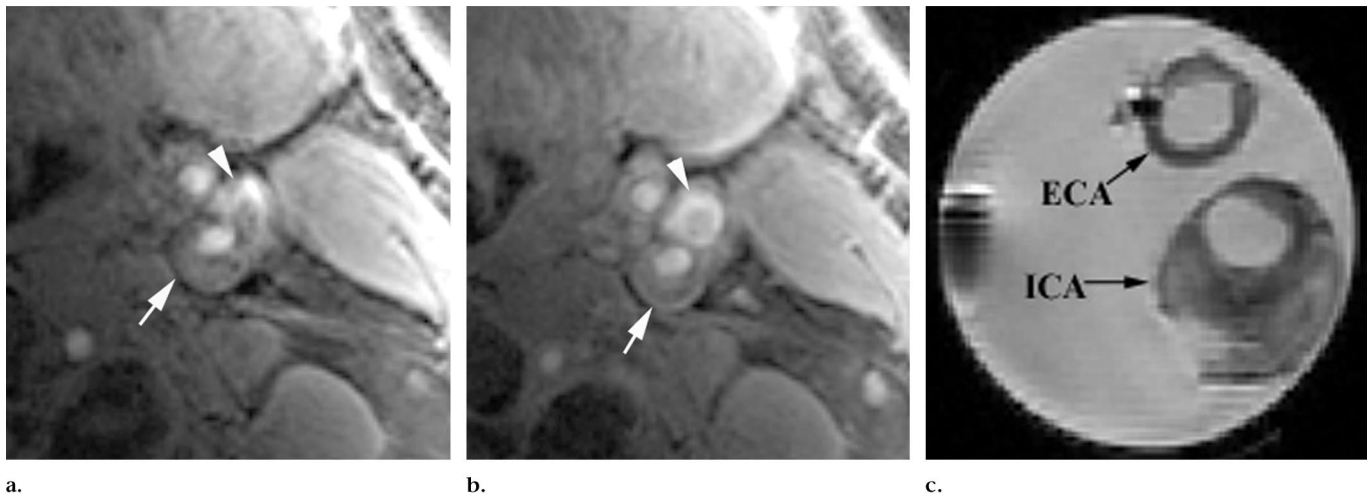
Three-dimensional fast GRE MR images of carotid artery. (a) On precontrast image, outer wall boundary of internal carotid artery (arrow) and jugular vein (arrowhead) are unclear. (b) On postcontrast image, outer wall boundary of internal carotid artery (arrow) is clearly delineated as a bright rim. Jugular vein (arrowhead) is better delineated than on a, with a clear vein-artery interface. Imaging parameters for a and b are 9.8/2.4 with a 13-cm field of view, 2-mm section thickness, matrix of 256 × 256, two signals acquired, and 20° flip angle. (c) Ex vivo image. ECA = external carotid artery, ICA = internal carotid artery. Imaging parameters are 9.8/2.4 with an 8-cm field of view, 1-mm section thickness, matrix of 256 × 256, two signals acquired, and 20° flip angle.
